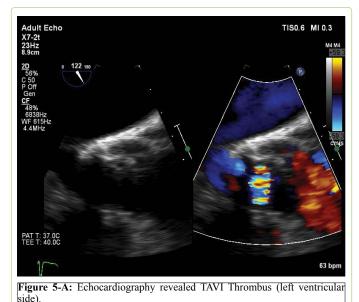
Echocardiography Doppler Day 1 post TAVI.
